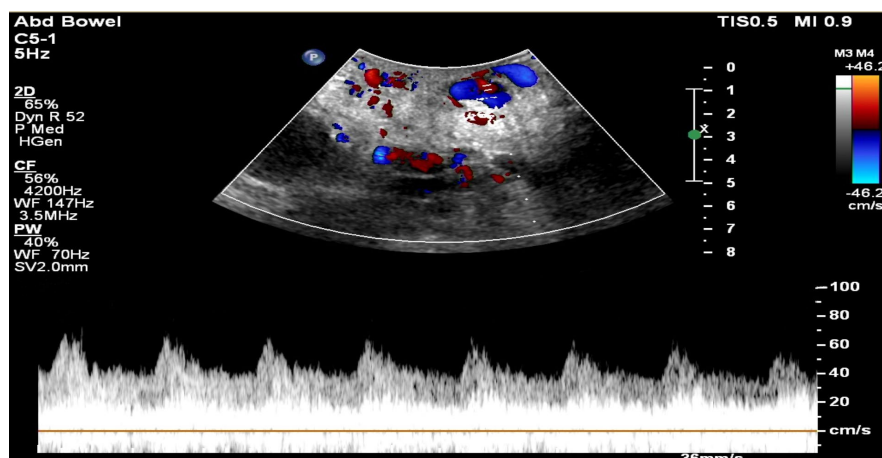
Continuous Wave Doppler (CWD) of blood vessels within the “mass” demonstrated a High-Velocity Low-Resistance (HVLR) blood flow spectrum.
